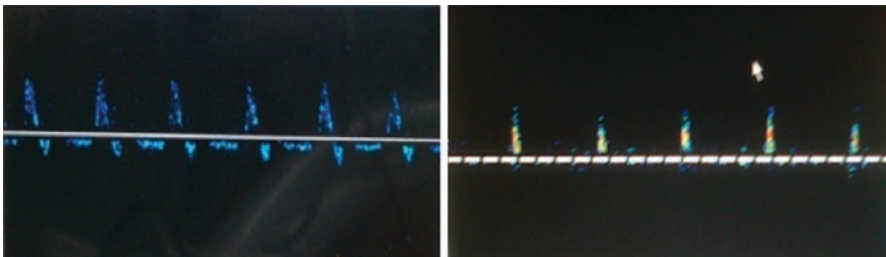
Spectral Doppler (TCD): Left: Reverberant blood flow; Right: Systolic spikes
